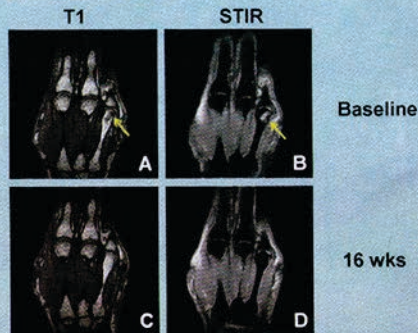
MRI of the right hand at baseline (A, B) and wk 16 (C, D) shows improvement of osteitis (arrows) in the fourth metacarpal head. The patient was a clinical responder at wks 12 and 52.
